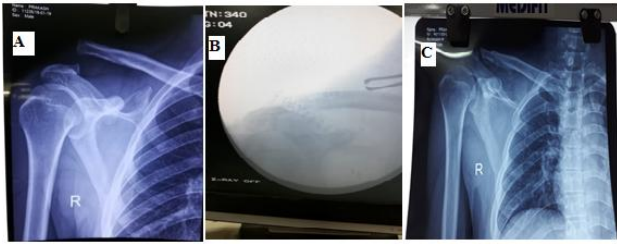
A) Pre op X-ray of patient, B) intra op reduction, C) follow up 6 weeks.
